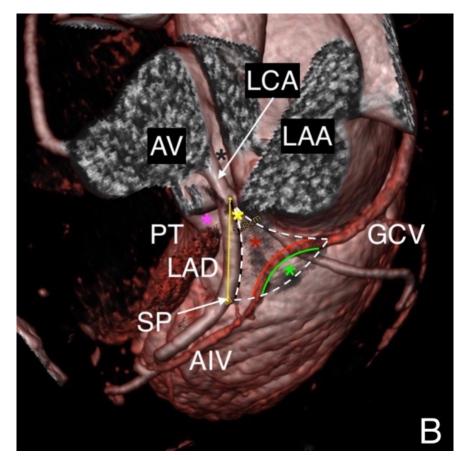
A – left ventricular summit in gross dissection at the level of the fibrous skeleton of the heart, B – LVS in an angio-CT rendered image. Abbreviations: LVS = left ventricular summit; LAD = left anterior descending artery; LCA – left coronary artery; Cx = circumflex branch of left coronary artery; GCV = great cardiac vein; AIV = anterior interventricular vein; SP= septal perforator; LAA = left atrial appendage; PT = pulmonary trunk, PV pulmonary valve, MV – mitral valve, AV – aortic valve. red asterisk – inaccessible area; green asterisk accessible area; violet asterisk - septal summit; black asterisk – aortiomitral continuity; yellow asterisk – apex of LVS.
